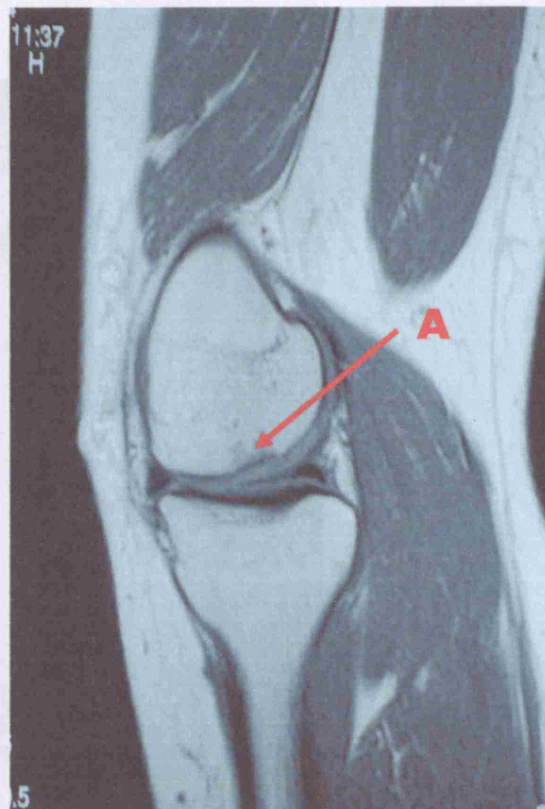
Figure VIIb. MRI (T1 weighted) of the same knee as in figure VIIa (sagittal view) demonstrating an osteochondral defect (A) of the medial femoral condyle with underlying 'bone bruising'.
